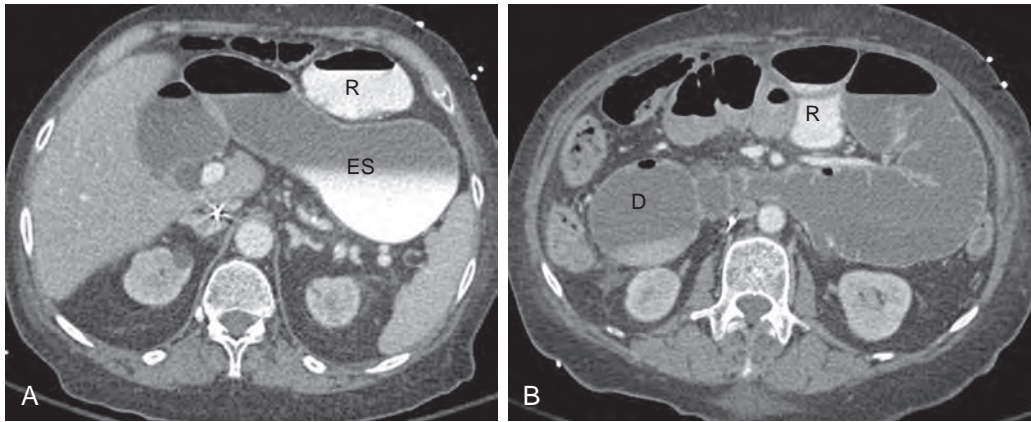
Small bowel obstruction following RYGB with obstruction of the common channel. A, B. Axial CT images following positive oral and IV contrast show marked dilation of the excluded stomach (ES) and duodenum (D) as well as the opacified Roux limb (R) caused by downstream obstruction of the common channel. Also note that oral contrast is present in the excluded stomach but not the duodenum because of staple line dehiscence more cephalad (not shown).
